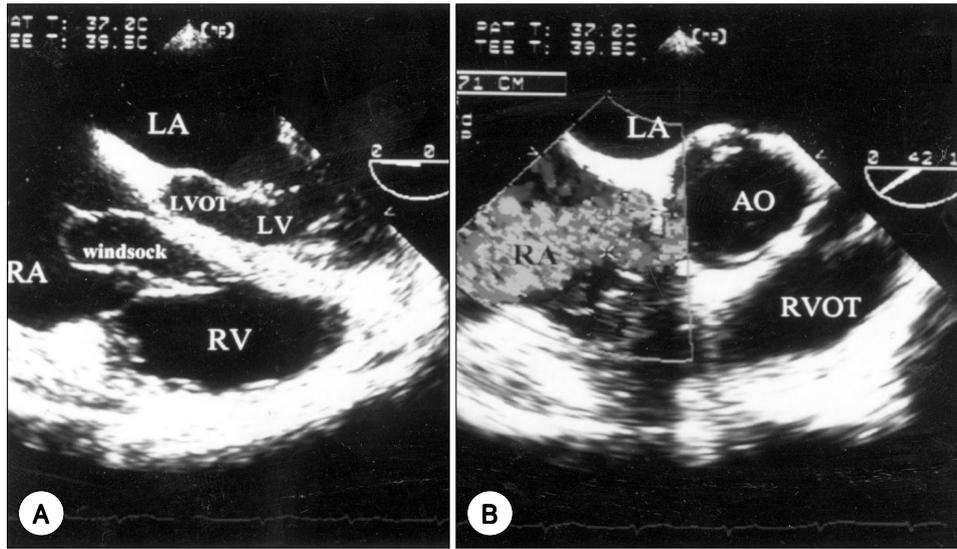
Transesophageal echocardiogram shows windsock-like aneurysm of sinus of Valsalva in horizontal view (A). Color jet from aorta into right atrium is observed (B).
